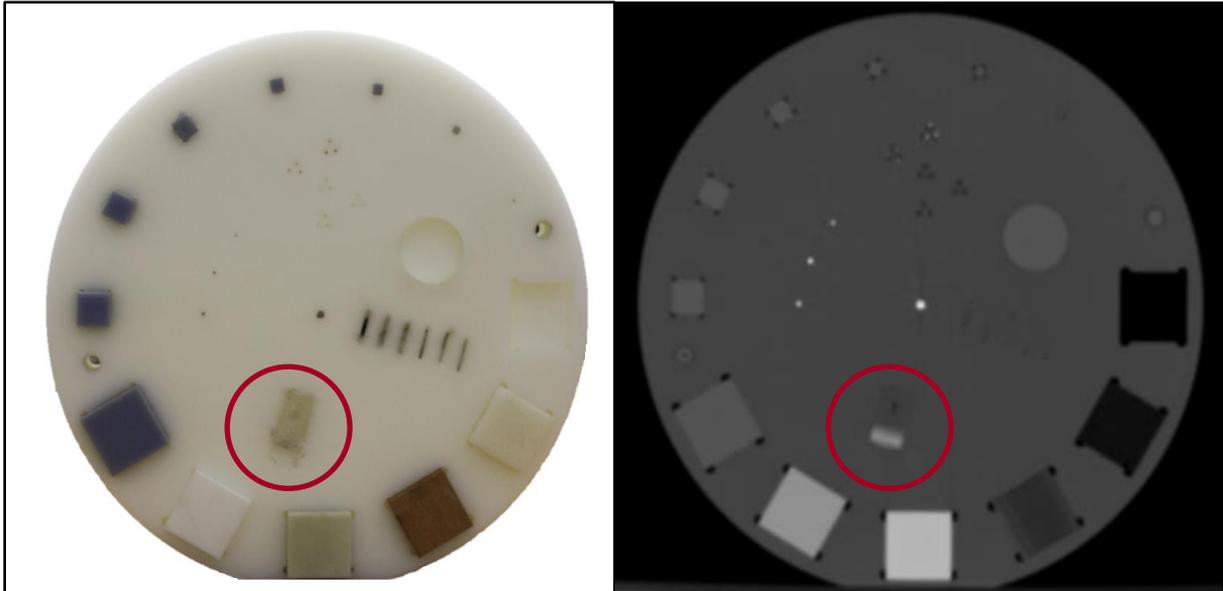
The red circle shows the location of ramp for CT slice thickness measurement.
